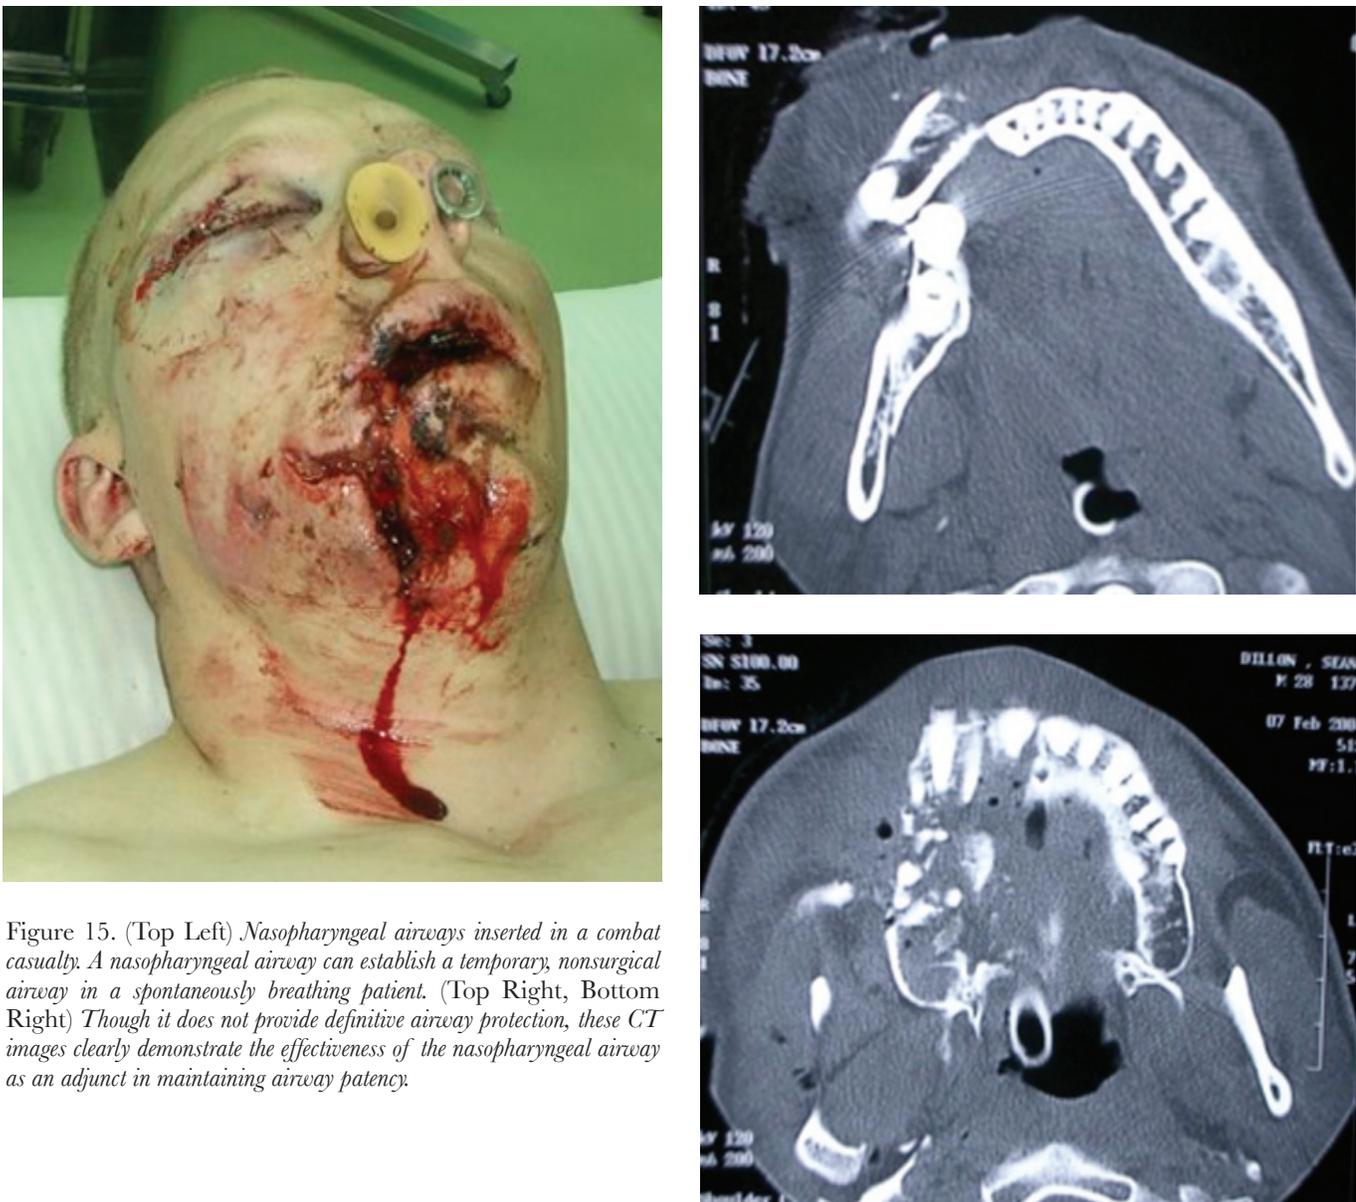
(Top Left) *Nasopharyngeal airways inserted in a combat casualty. A nasopharyngeal airway can establish a temporary, nonsurgical airway in a spontaneously breathing patient.* (Top Right, Bottom Right) *Though it does not provide definitive airway protection, these CT images clearly demonstrate the effectiveness of the nasopharyngeal airway as an adjunct in maintaining airway patency.*
